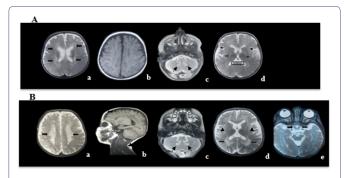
Panel A: Brain MRI of the sister (IV11). Axial T2-weighted image (Panel A,a; A,c; A,d) that shows T2 hypersignal in the bilateral periventricular area (A,a), in the posterior arms of the internal capsule (A,d, arrow), a thin corpus callosum (A,d, rectangle), damage to the dentate nuclei (A,c, dot arrow), and global cortico-subcortical atrophy (A,c, stars). Axial T1-weighted image (Panel A,b) shows cortico-subcortical atrophy. Panel B: Brain MRI of the brother (IV12). Sagittal T1-weighted image (panel B,b) that shows cortico-subcortical atrophy. Axial T2-weighted images (Panel B,a; B,c; B,d; B,e) show a tigroid pattern of the periventricular hyper signal (B,a, large arrow), which appears in T1 hypo signal with atrophy of the sylvian valleys (B, b, arrowhead) and cerebral cortico-subcortical atrophy (B,b), involvement of the dentate nuclei (B, d, dot arrow), and hypertrophy of the optic nerves (B,e, arrow).
